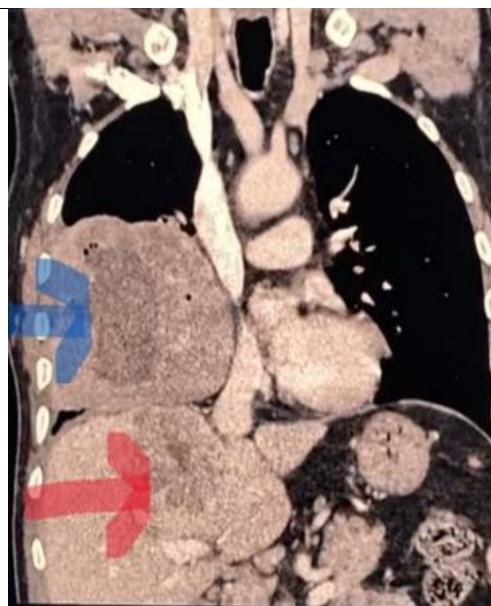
Chest X-ray Showing Mass lesion in Right Lung (blue arrow)
